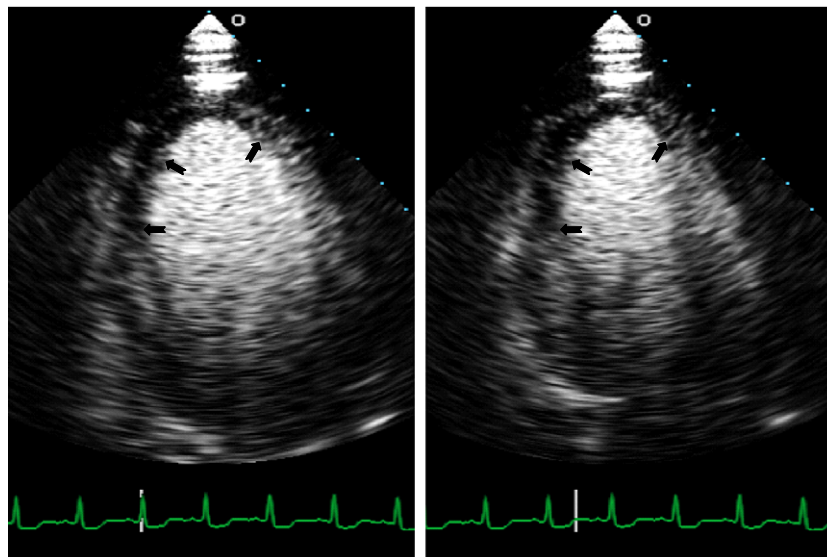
Real-time myocardial contrast echocardiographic images of a patient with first acute anterior myocardial infarction at end-diastole (left panel) and end-systole (right panel). This patient received conservative therapy due to late arrival to our hospital and follow-up coronary angiography showed 95% stenosis of left anterior descending coronary artery. Arrows showed mid-septal, apical-septal and apex segments without contrast opacification i.e. non-viable myocardium, which correlated well with non-viable area at follow up two-dimensional echocardiograms 4-month later.
